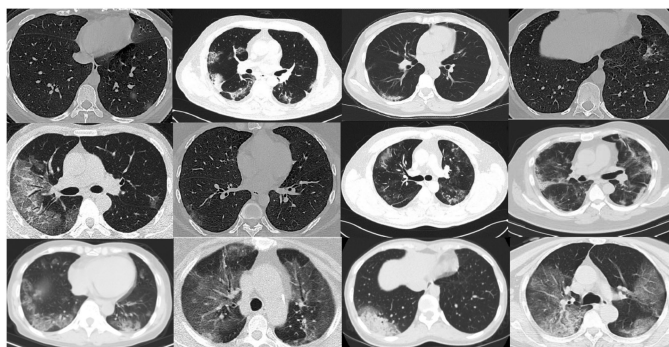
A view of chest-CT scan images of COVID-19 disease in patients.
